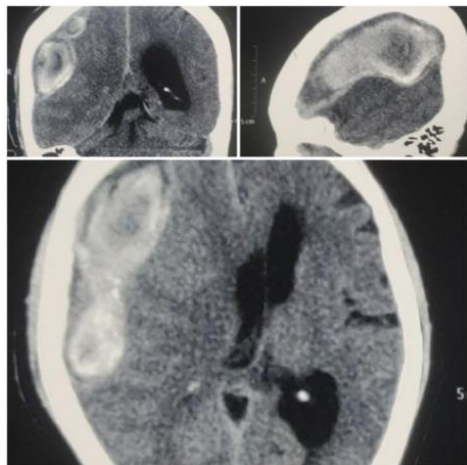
CT of Brain showing mixed density lesion with a calcified rim in the right fronto-parietal region
